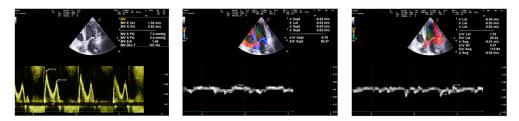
c.3. Diastolic dysfunction in a case with restrictive cardiomyopathy due to amyloidosis. Left: E/A ratio 1.46, E=1.34 m/s, DT=147 ms (PW Doppler, apical 4-chambers view). Middle and right: reduced velocities of myocardium movement e's=3 cm/s, e'l=5 cm/s, E/E'av=56 (tissue Doppler, apical 4-chambers view)
